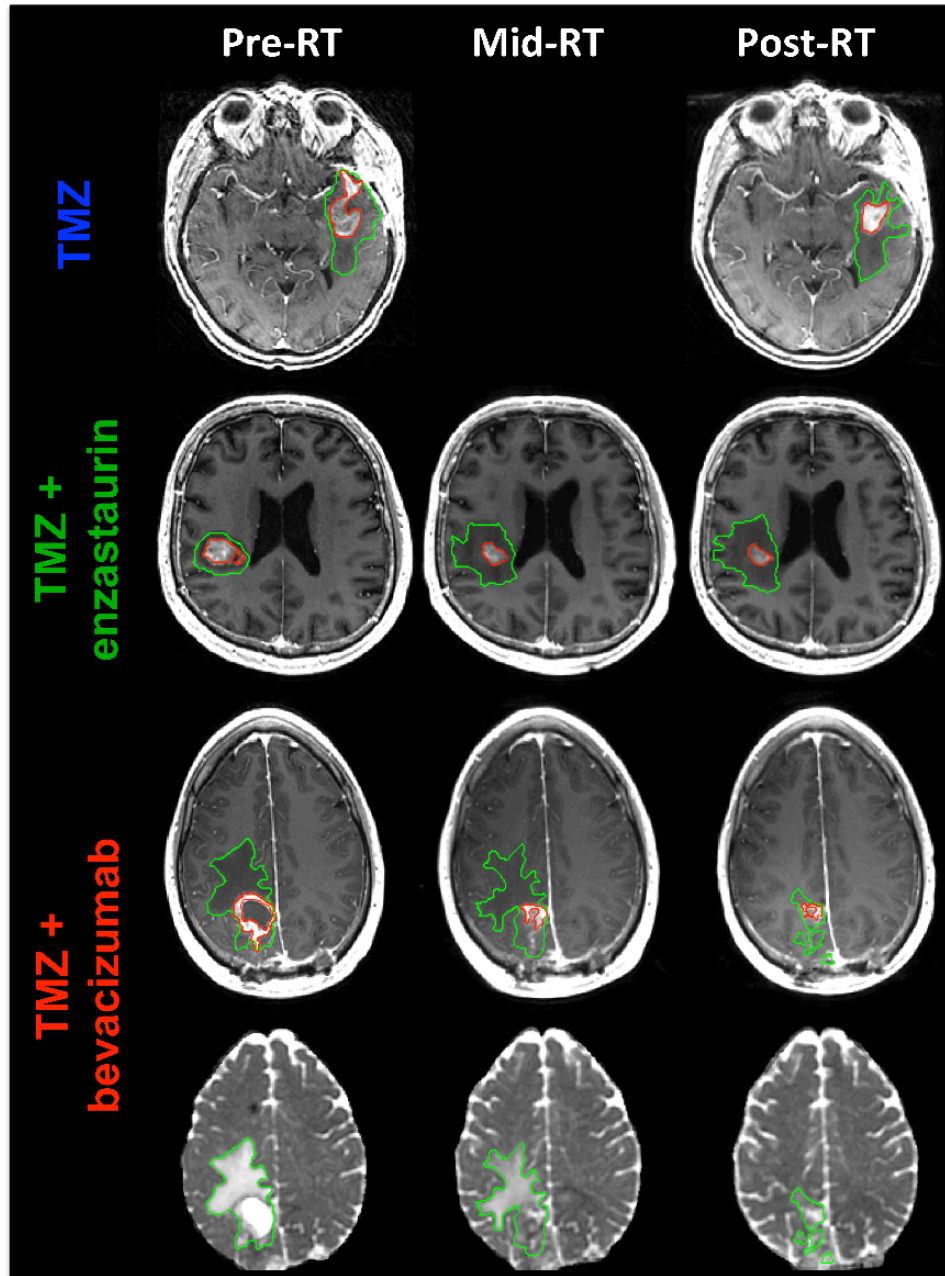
Representative T1-weighted post-Gd images at pre-, mid-, and post-RT with contrast-enhancing lesion (CEL, red) and T2-hyperintensity lesion (T2L, green) overlay. ADC images were shown for the patient in the TMZ+bev cohort. Compared to the patients in the TMZ and TMZ+enza cohorts, there was a dramatic decrease in both CEL and T2L from pre- to post-RT for the patients in the TMZ+bev cohort. While the largest change in CEL happened from pre- to mid-RT, which was only 2 weeks into bevacizumab, the largest change in T2L happened from mid-RT to post-RT.
